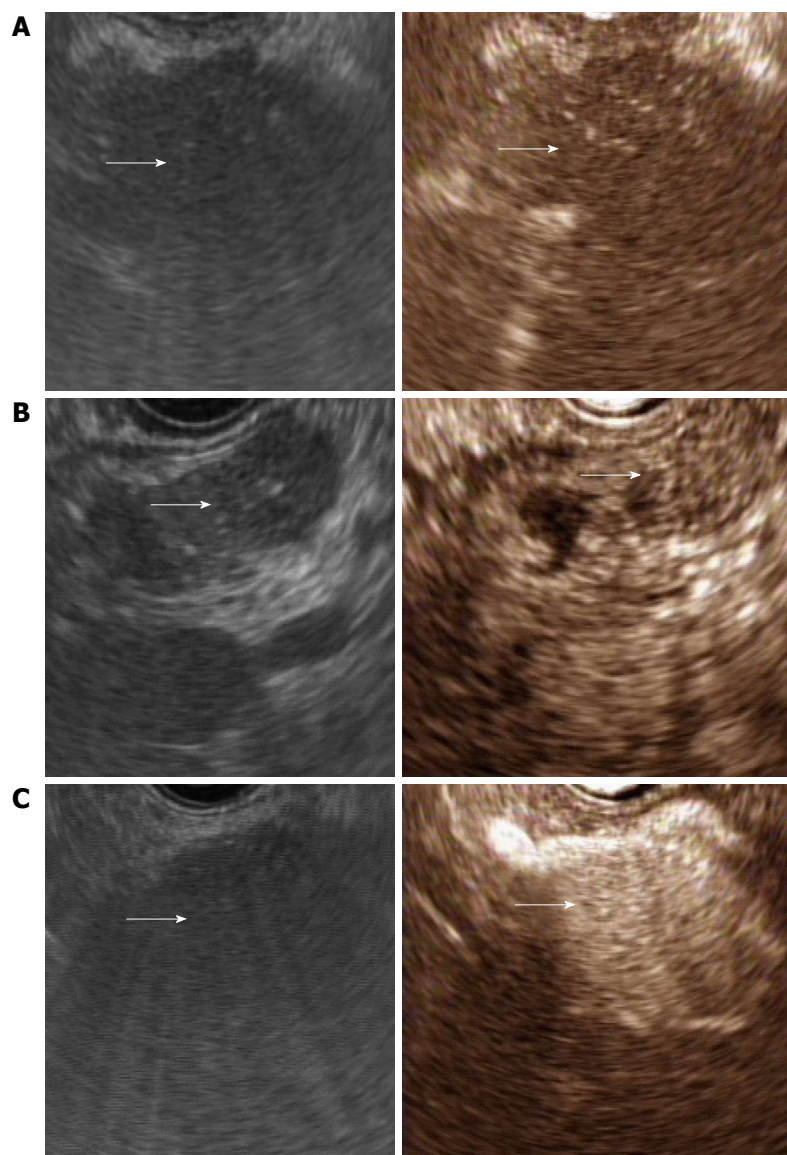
Conventional endoscopic ultrasonography (left) and contrast-enhanced harmonic endoscopic ultrasonography (right). These pictures showed a typical example of a hypoenhancement pattern (A), an isoenhancement pattern (B), and hyperenhancement pattern (C).
